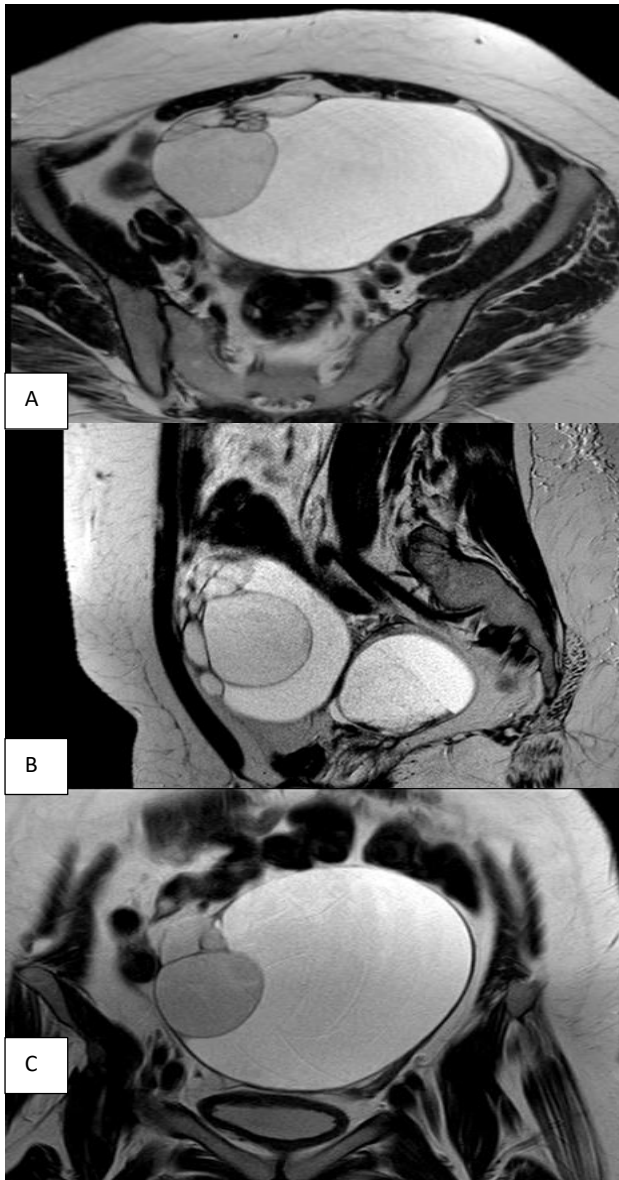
(A-C): Axial, sagittal and coronal MRI T2W images showing large hyperintense lesion with multiple loculi and septa exhibited variable signal intensities within.
